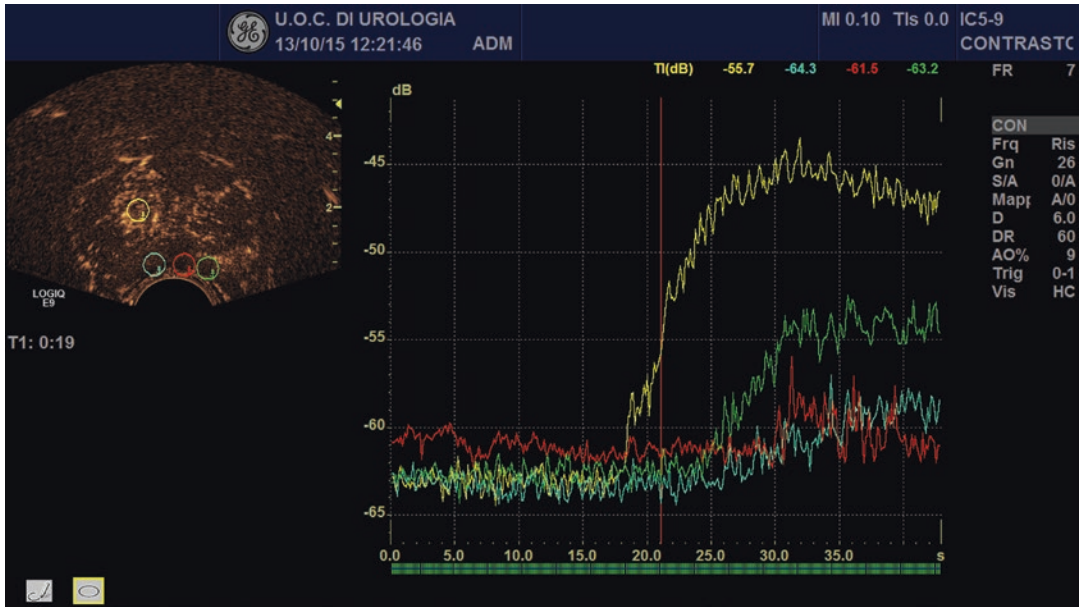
Visual and quantitative analysis of SonoVue® concentration in the prostate after intravenous administration of ultrasound contrast medium: the markers evaluate the concentration of SonoVue® in different areas of the gland
